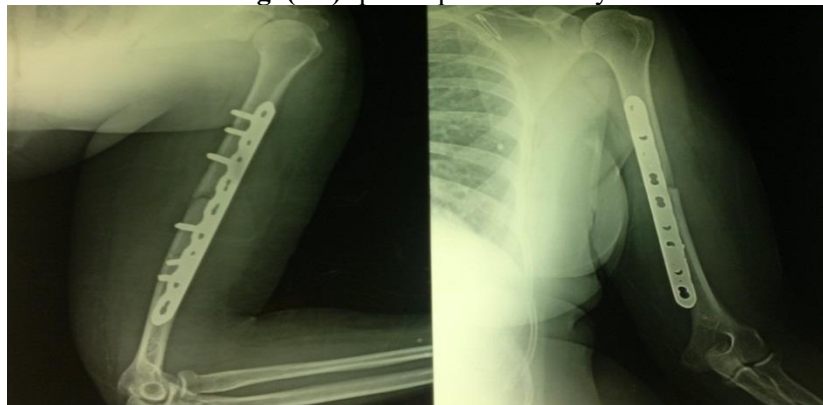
b): Immediate after operation X-ray
